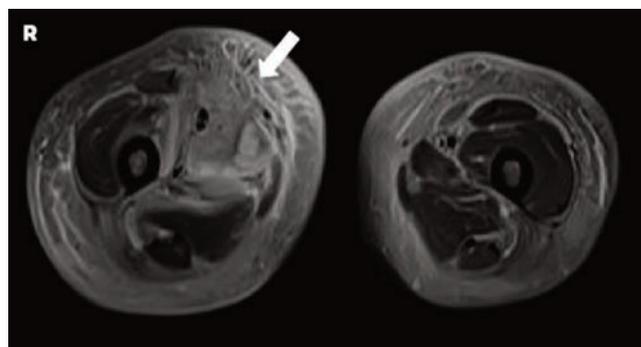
Coronal postcontrast-enhanced T1-weighted fat suppressed image confirming intense muscle, fascial and subcutaneous enhancement within the right upper medial thigh with focal central area of muscular non-enhancement (arrow)
